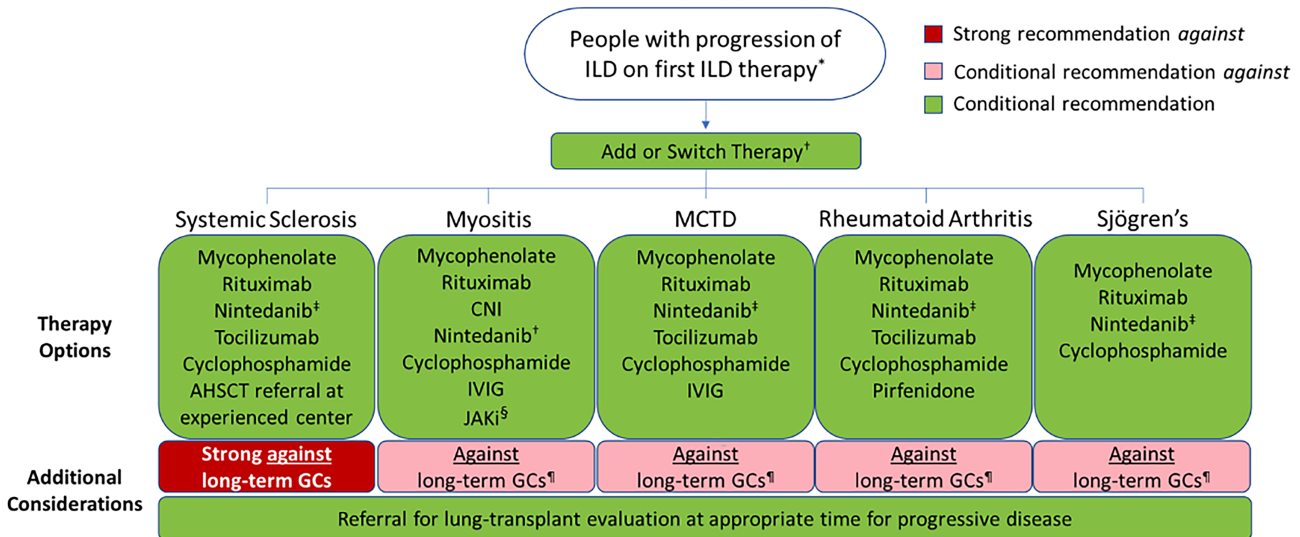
Management of SARD-ILD with progression of ILD despite first ILD therapy. * If intolerance leads to suboptimal dosing of first-line therapy, consider switching to an alternative first-line therapy. † Therapies are generally listed in order based on a hierarchy established by head-to-head votes, but decisions depend on specific clinical situations. Decision on whether to switch therapy or add to current therapy depends on current therapy and on which therapy is being initiated. Cyclophosphamide is not typically used in combination with other therapies, whereas others may be used individually or in combination. ‡ Decision on use of nintedanib vs immunosuppression depends on pace of progression and amount of fibrotic disease or presence of a usual interstitial pneumonia pattern on CT chest. § JAKi conditionally recommended as an option particularly in patients with anti-MDA-5. ¶ Short-term glucocorticoids may be of use in some patients with disease flares or as a bridge when switching therapy. AHSCT, autologous hematopoietic stem cell transplantation; CNI, calcineurin inhibitor; CT, computed tomography; GC, glucocorticoid; ILD, interstitial lung disease; IVIG, intravenous immunoglobulin; JAKi, JAK inhibitor; MCTD, mixed connective tissue disease; MDA-5, melanoma differentiation-associated protein 5; SARD, systemic autoimmune rheumatic disease.
